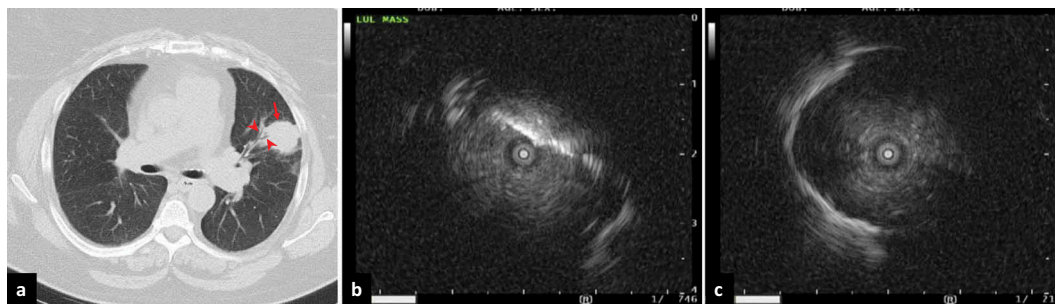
Tangential versus central ('bronchus sign') airways, and eccentric versus concentric radial endobronchial ultrasound images. A 60-year-old woman with a left upper-lobe mass measuring 3.9×3.1 cm on CT (a, arrow) with multiple airways leading toward it (arrowheads), resulting in both eccentric (b) and concentric (c) images on radial endobronchial ultrasound. Cytology revealed squamous cell carcinoma.
